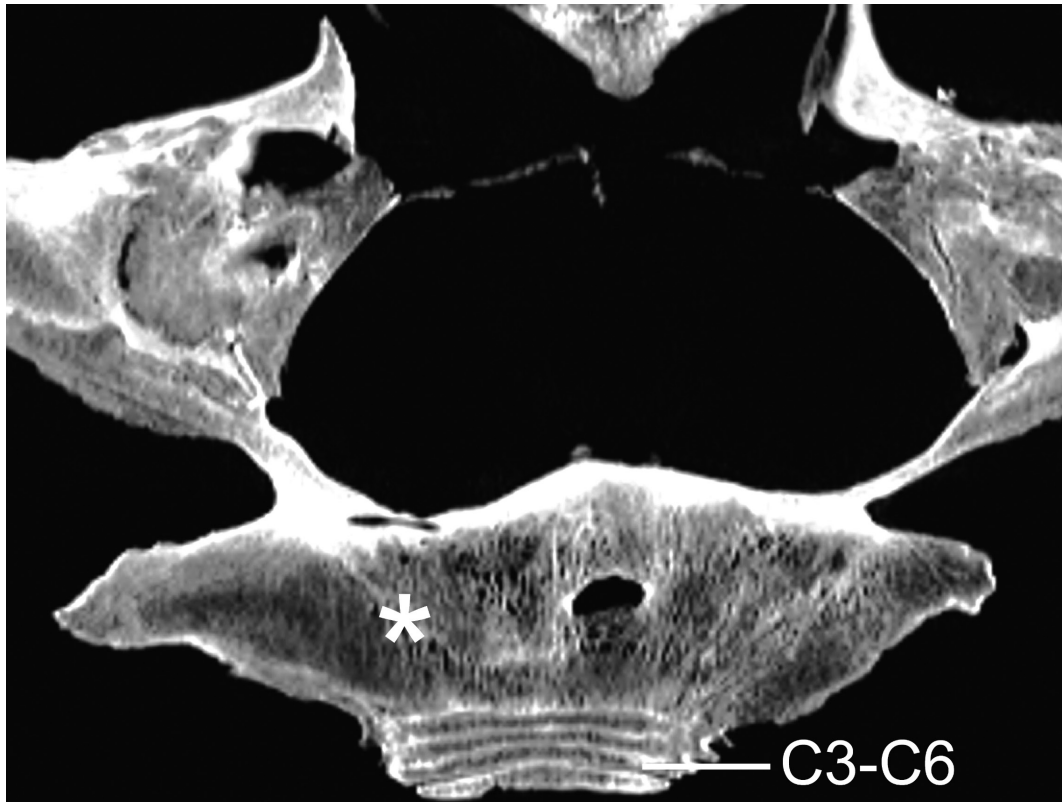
Dorsal plane of the caudal region of the skull and the first six cervical vertebrae on computed tomography. The fused atlanto-occipital (A-O) joint shows a uniform transition (*) between the occipital condyles of the skull and the atlas and axis. The third to sixth cervical vertebrae (C3 to C6) are clearly defined.
